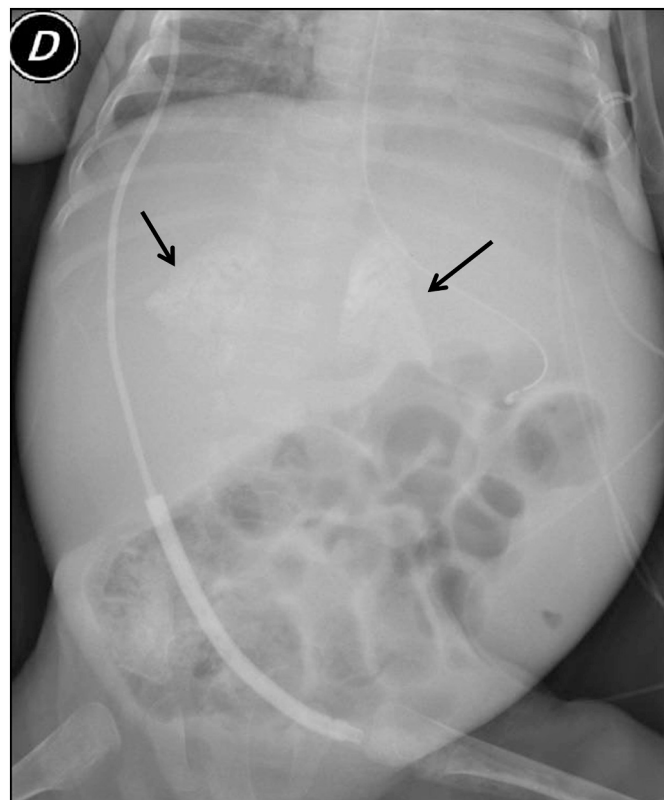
Abdominal X-ray with calcific adrenal glands (arrows).
